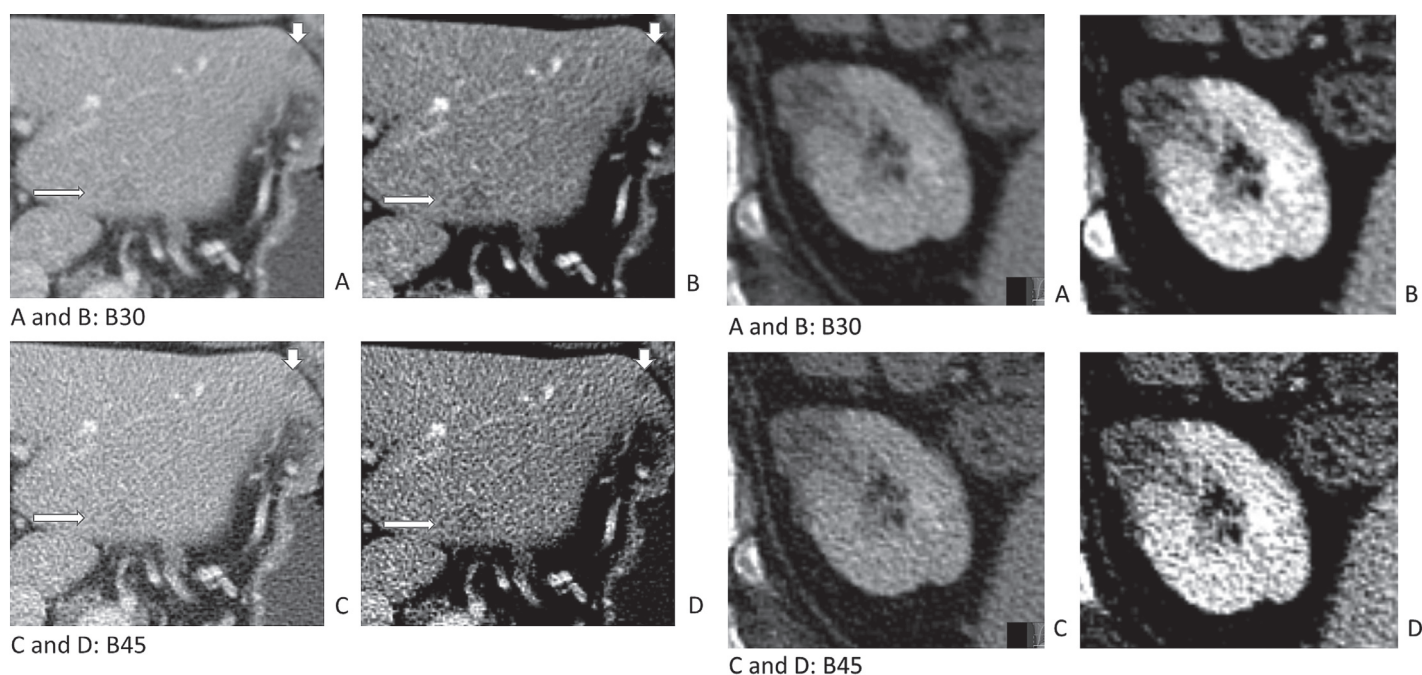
The figure shows two different window settings in A and B for the B30 kernel reconstruction, C and D for B45 of the CT images of this 62-year-old patient with primary neuroendocrine tumour of the small intestine (window levels are C:50, W:380 in A and C, C: 120, W: 200 in B and D). Two small liver lesions are shown in the left liver. The one anteriorly (thick arrow) is quite easy to see in all reconstructions. The other lesion (thin arrow) more posteriorly and medially is difficult to see. A change in window level helps the demarcation in the B30 algorithm. In the B45 reconstruction, the noise makes it much harder to detect it in both window settings.
